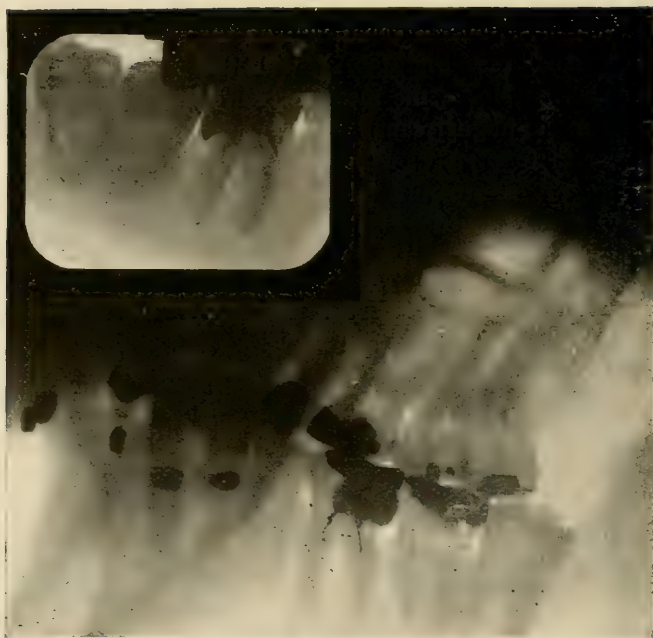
Two radiographs of the same lower first molar. In one the canal filling seems to pass through the side of the root; in the other it seems to follow the canal.
